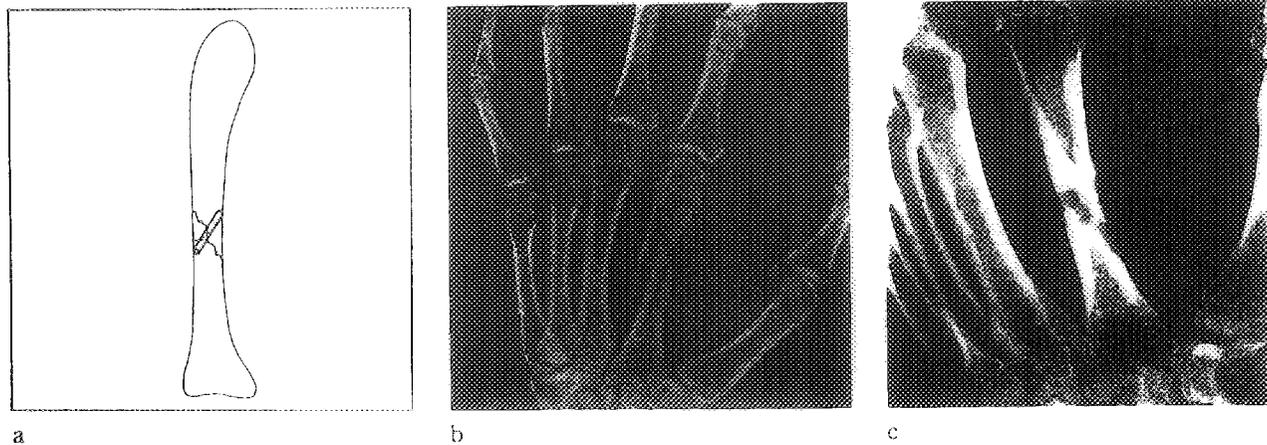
Fixation of diaphyseal fracture of the metacarpal bone (a). Radiograph of a displaced diaphyseal fracture of the second metacarpal bone seen on admission (b) and three months after fixation with one 2 by 25 mm BIOFIX®-rod (c).
